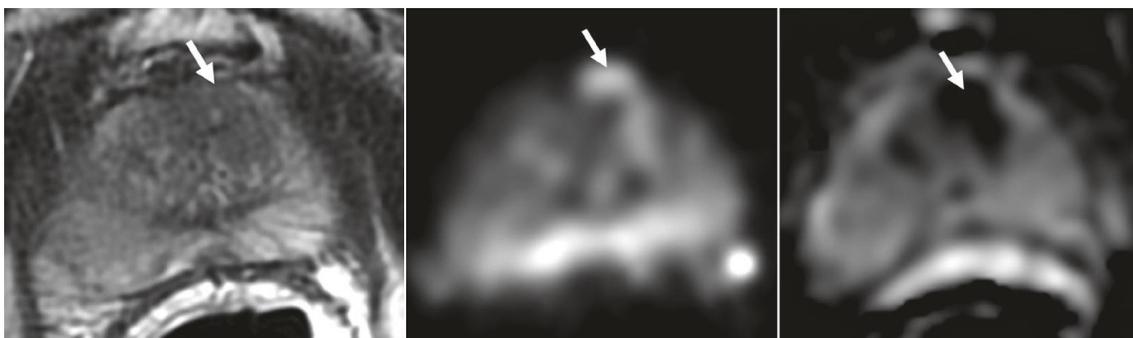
PI-RADS upgrading from 3 to 4 category in TZ. First, axial T2WI. Second, axial b1400 DWI. Third, ADC map. There is a heterogenous signal intensity area in the left anterior TZ with obscured margins (arrows). The focal lesion shows high signal on DWI and low signal in ADC with longest diameter  $\geq 1.5$  cm consistent with a DWI component score of 5. Obtained from (12).
